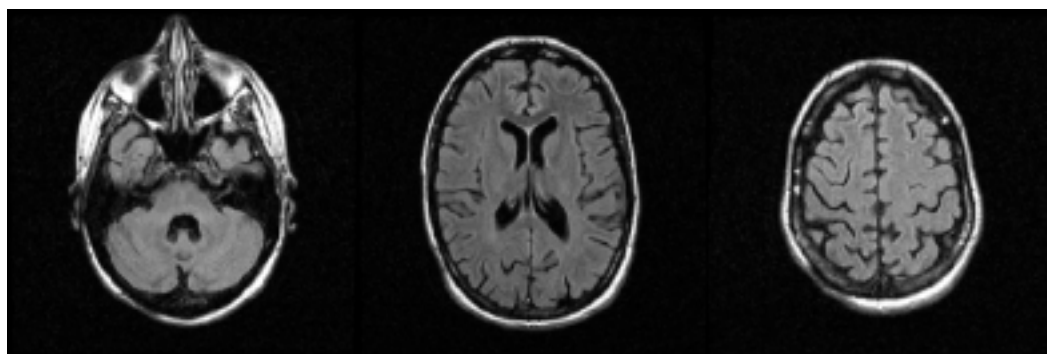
Brain MRI scans of Patient 3 four weeks after treatment with intravenous cyclophosphamide and plasmapheresis. T2 FLAIR imaging shows complete resolution of all high signal intensities compared with Figure 3A.
